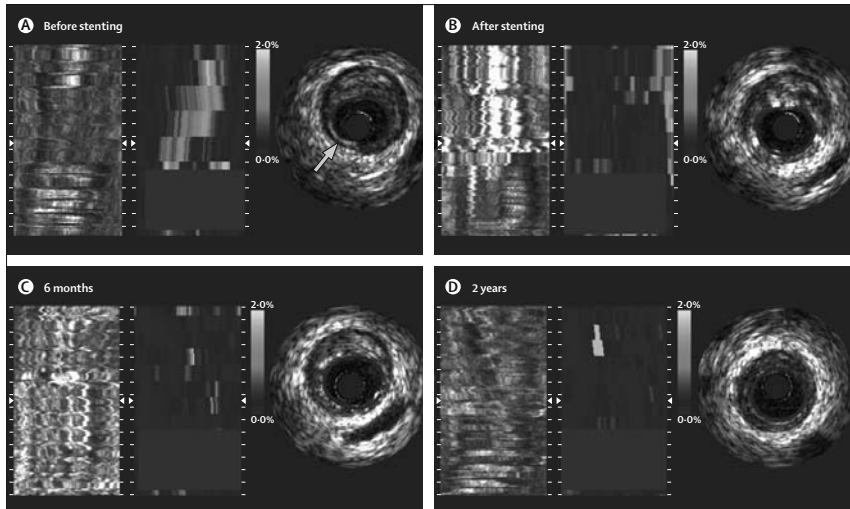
Sequential changes in strain assessed by intravascular ultrasound palpography
